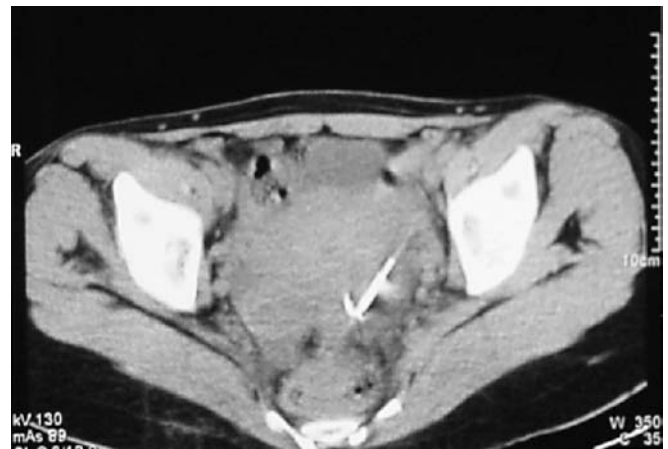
CT scan showing the IUD on the urinary bladder wall
